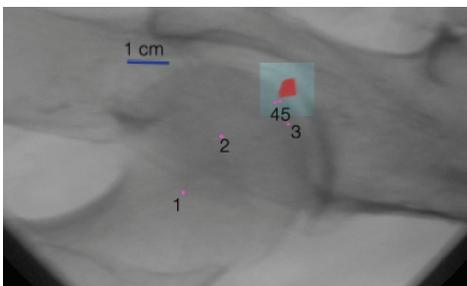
Without X-Grid, 5 fluoroscopic X-rays were needed in order to localize the hip target.
